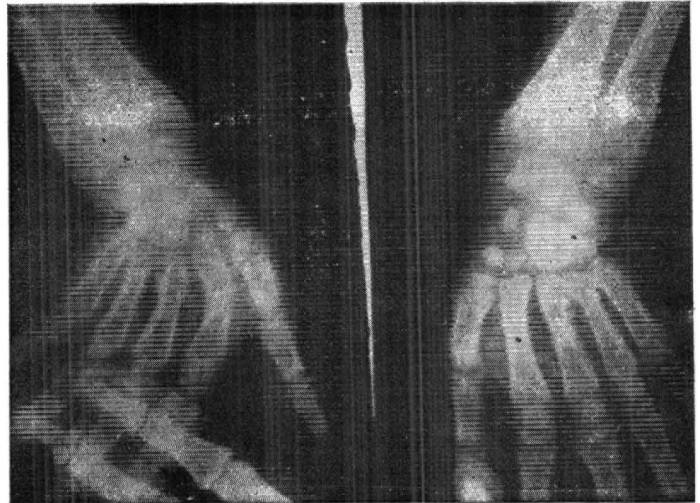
X-Ray wrists and hands-showing osteoporosis, thinning of cortex and separation of epiphysis.
